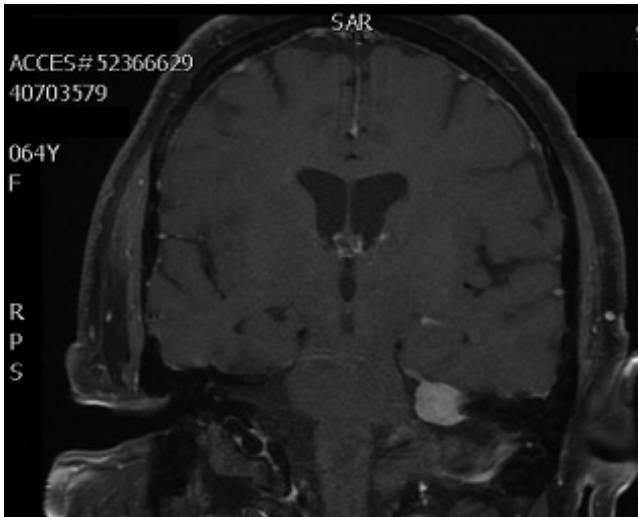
MRI scan of a patient who presented with frequent headaches and episodic vertigo but was found to have a meningioma in the cerebellopontine angle.
